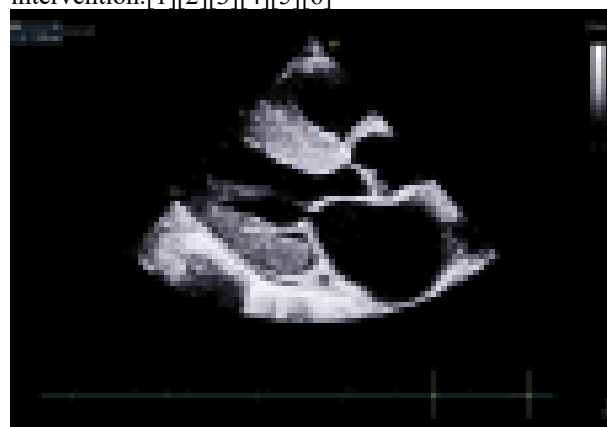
Cardiac Amyloidosis on Transthoracic Echocardiogram.
